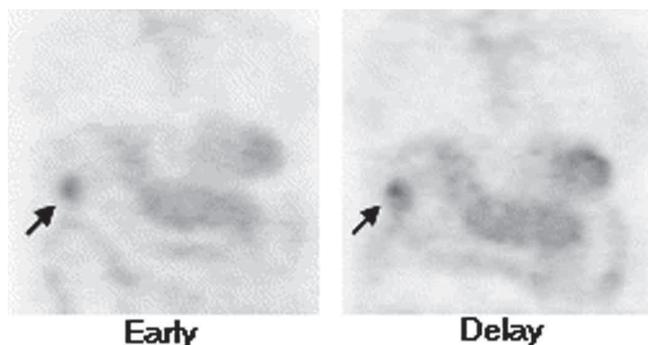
The early and delay FDG PET images for an 82-year-old male patient (patient #3). The tumor at the right liver lobe (arrow) has better lesion/background ratio in the 2h-delay image. This tumor was confirmed in the follow-up angiography.
